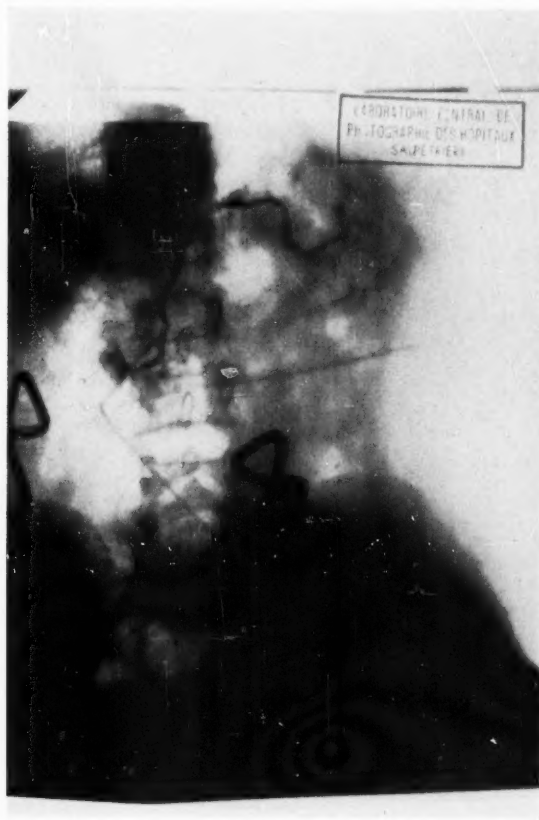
Stricture of the Wirsung's duct at the pancreatic isthmus. In more than half of our cases, our Roentgenograms have revealed a narrowing of the Wirsung in the segment that crosses the isthmus.
